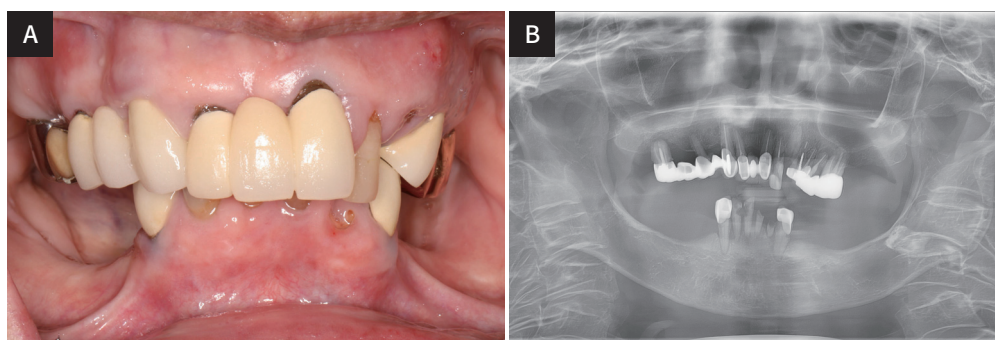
Pretreatment. (A) Intraoral photograph: frontal view, (B) Panoramic radiograph.
